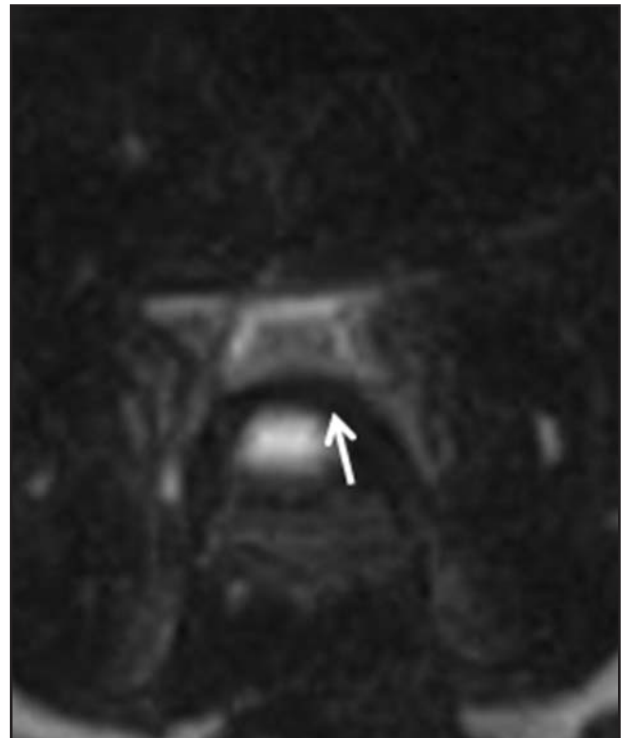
Transverse T2-weighted image obtained during MRI of the caudal portion of the cervical vertebrae of a clinically normal Doberman Pinscher. Disk-associated compression of the spinal cord is characterized by deviation or distortion of the spinal cord (arrow).
